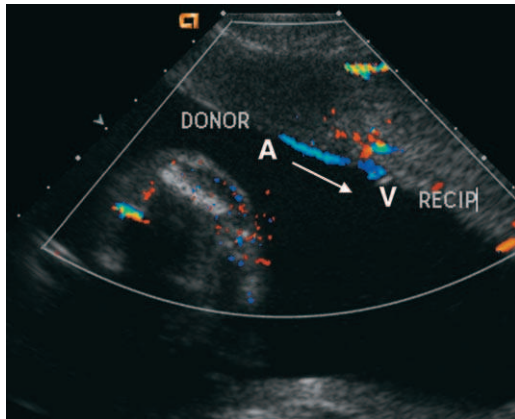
Color Doppler sonogram of an arteriovenous anastomosis with flow in the direction of the arrows. There is pulsatile flow in the afferent arterial limb (A) from the donor and continuous monophasic flow in the efferent venous limb (V) toward the recipient.
